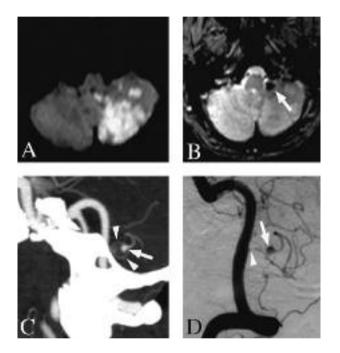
(A) Diffusion Weighted MRI shows acute left cerebellar PICA infarction. (B) T2-gradient echo-weighted images reveal a large hypointensity (arrow) which suggests a left PICA aneurysm. (C) CT angiography shows a partial thrombus (arrow) and a circulating lumen in the aneurysm with annular contrast enhancement (arrowheads). (D) Selective angiography of the left vertebral artery (lateral view) confirms proximal PICA occlusion (arrowhead) followed by aneurysm (white arrow). Aneurysm and the distal segment of the left PICA are supplied by collateral circulation.
